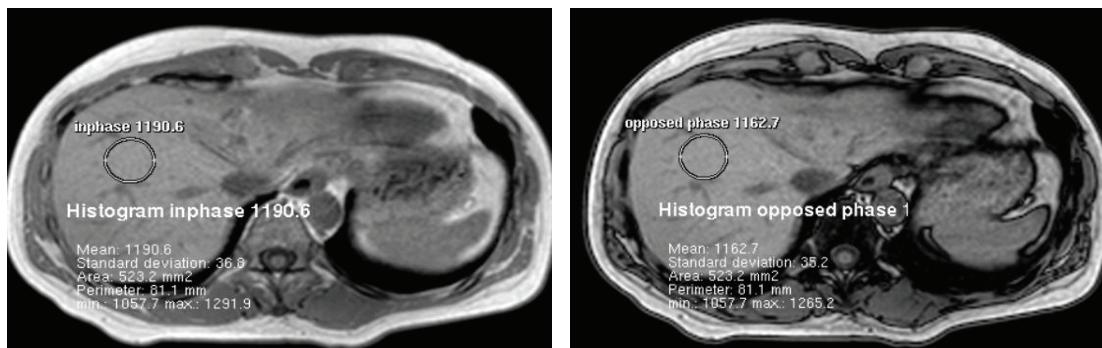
Chemical shift MRI for fat quantification in normal liver
